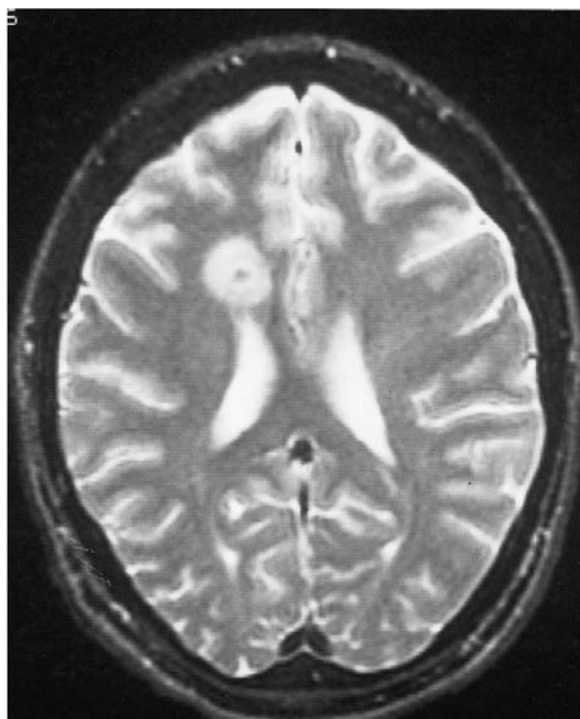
Axial T_2 -weighted cranial MRI scan showing right frontal tuberculoma with surrounding edema. (Courtesy of Dr J.C. McArthur.)
